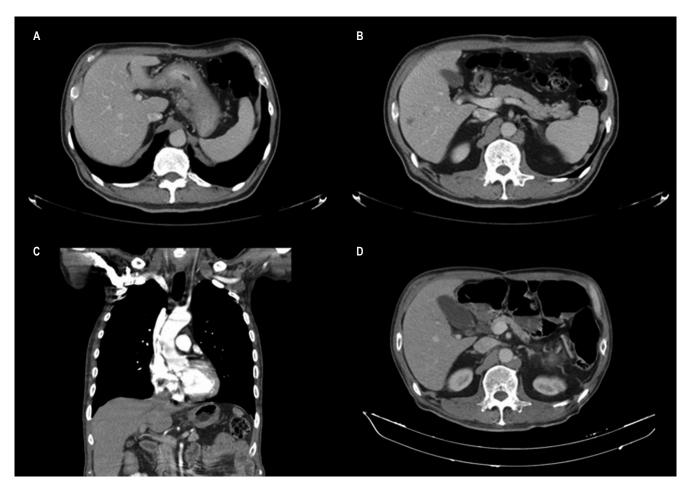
CT scan studies performed for tumor pathology follow-up purposes. A. Diffuse stomach wall thickening plus a 31 x 17 mm matted lymph node with extramural extension. B. Up to 10 mm focal hypodense hepatic lesions in segments IV and VI of the liver. C. Decreased gastric chamber thickening and adenopathies, there are no hepatic nodules or new lesions. D. Post gastrectomy changes, normal liver size, morphology, density and contour, without focal lesions or other tumor growth lesions.
